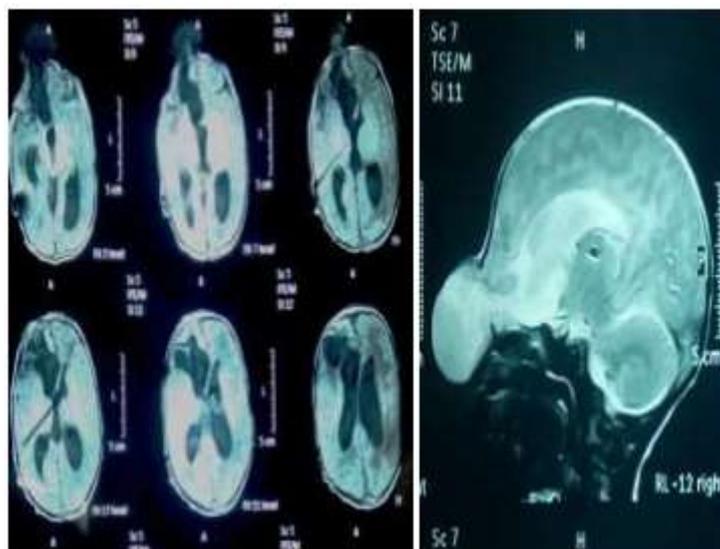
MRI shows communication between encephalocele and lateral ventricle
